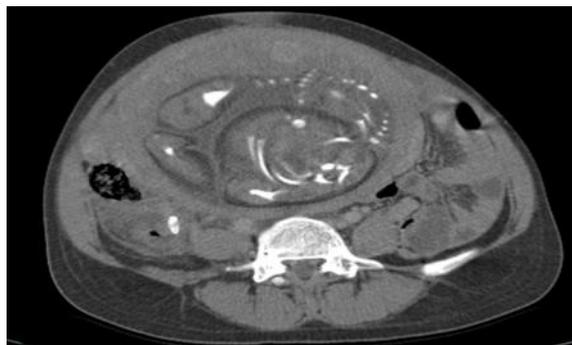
CT scan of the abdomen in injected axial sections showing the presence of an stercolith at the level of the FID (arrow), with appendage not visible
